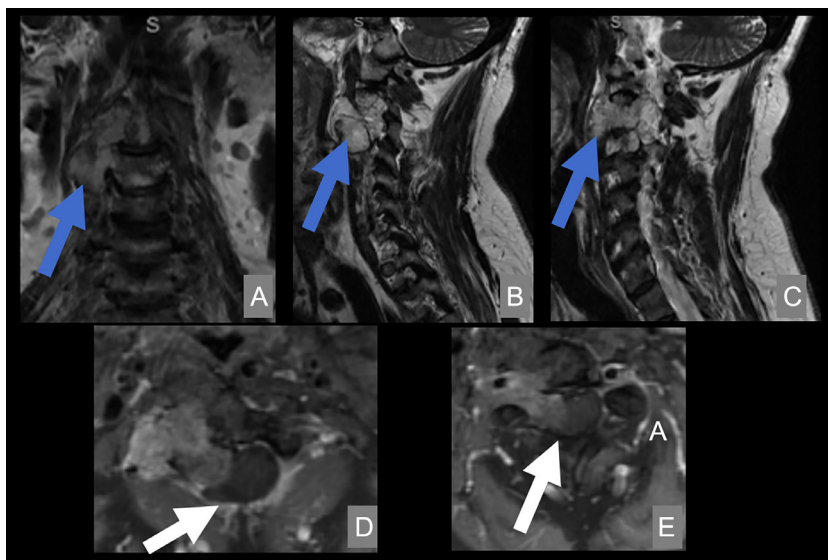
Preoperative coronal (A) and sagittal (B and C) MRI images, T2-weighted, revealing an expansive solid soft tissue lesion (blue arrows) situated at the right C2–C3 paravertebral region, associated with bone erosions. Additionally, it displaces and compresses the right vertebral artery. In the axial T1-weighted image with gadolinium (D and E), the extension of the lesion into the interior of the spinal canal is evident, leading to a reduction in its diameter (white arrows).
